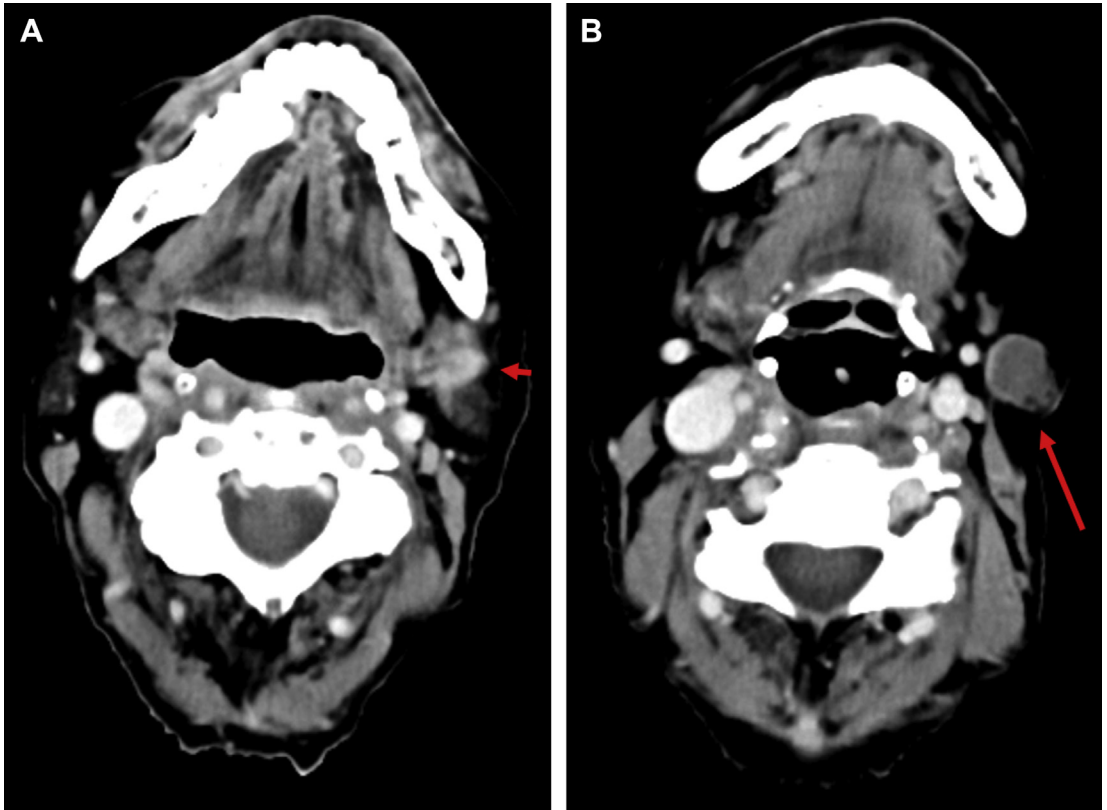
Adenocarcinoma of the left submandibular gland in a 51-year-old woman with palpable nodule. Contrast-enhanced CT shows areas of hyperattenuation superiorly (*short arrow, A*) and cystic change more inferiorly (*long arrow, B*).
